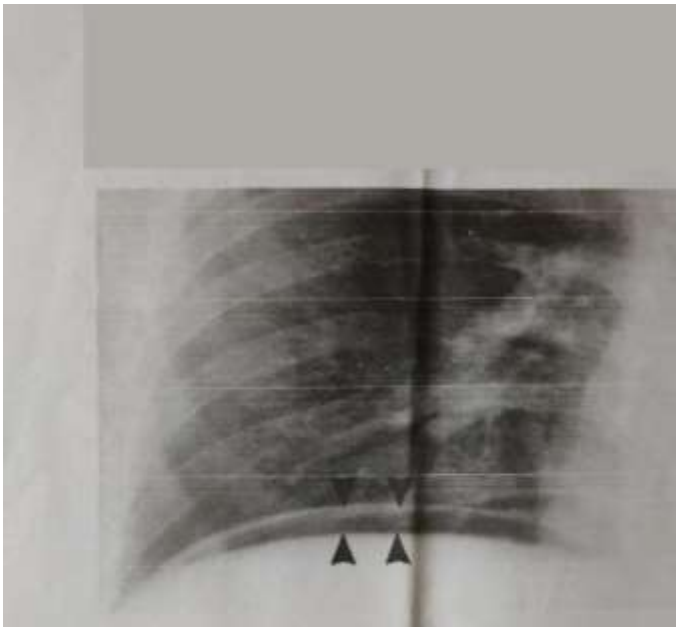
Poster anterior radiograph of right hemi diaphragm showing the most extensive pneumoperitoneum detected in our series after laparoscopic cholecystectomy. Perpendicular measurement between diaphragm and liver (arrowheads) is 9 mm, corresponding to mild pneumoperitoneum.
